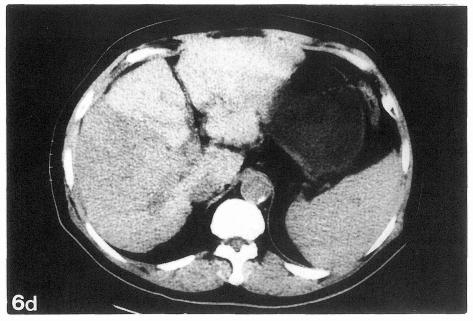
Case 2: US (a), CT (b) and scintigraphy (c) revealed one extrahepatic tumor in the abdominal cavity and a massive tumor in the anterior liver segment (d).
